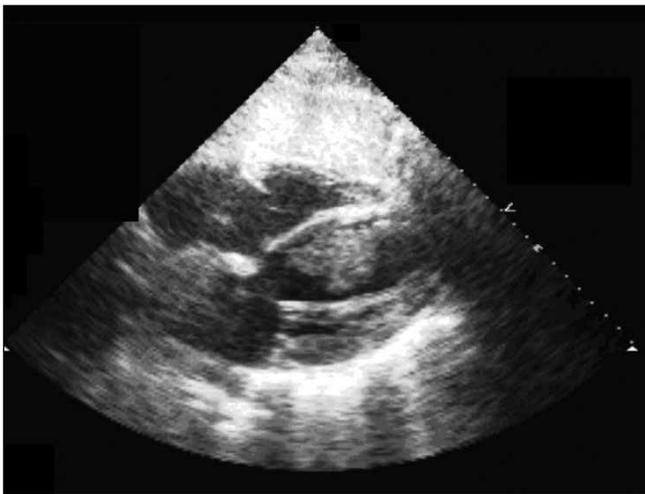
In another view, the echocardiogram shows a large mobile thrombus within the left ventricular cavity.
